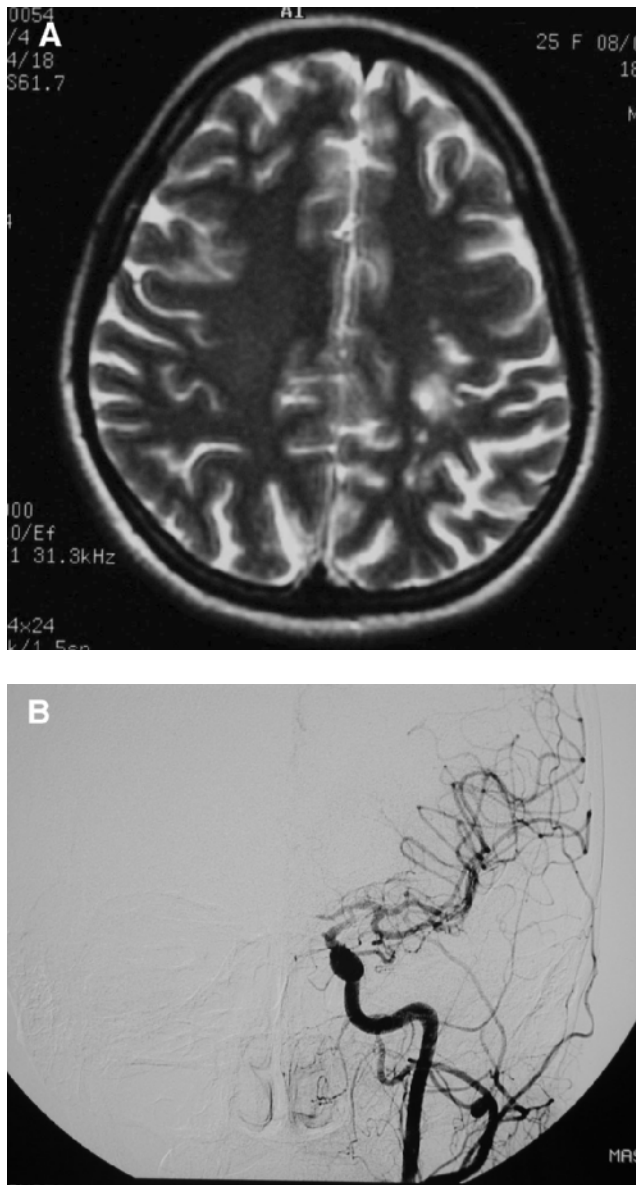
(A) MR T2-weighted spin-echo axial scan: hyperintense multiple ischemic lesions in the left frontal-parietal white matter. (B) Conventional angiography: lack of visualization of the left MCA.
